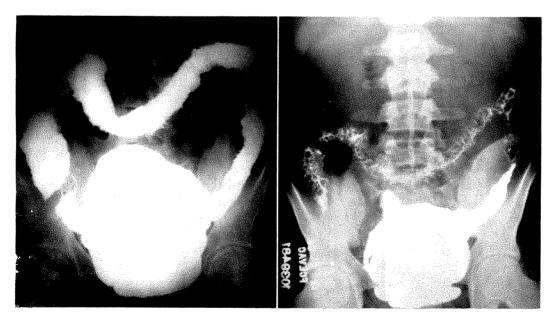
Ulcerative colitis type 2; diffuse ulcerative colitis involving the entire colon above and including the descending portion; results of proctoscopic examination negative except for a single small rectal polyp; left, roentgenogram of colon distended with opaque enema; right, after evacuation of opaque enema.
